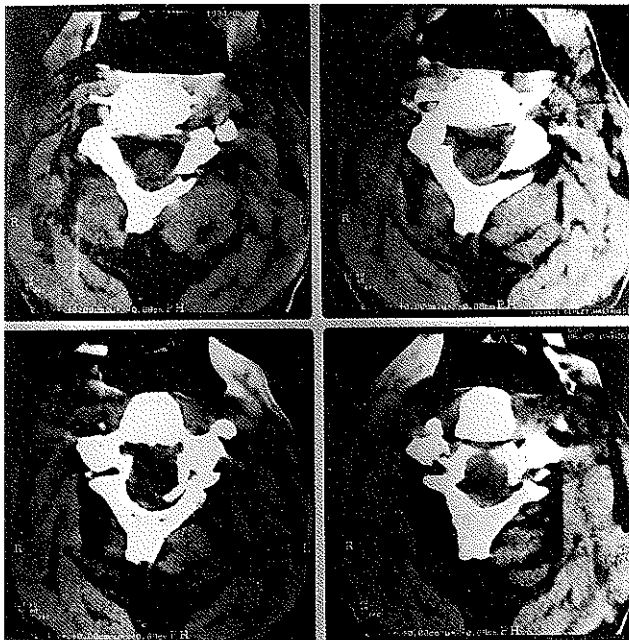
Laminar fracture of C3 and bilateral locked facet joints were seen on CT at the level of C3-C4. Corpus of C3 was totally in front of C4 and seen together at the same level.
